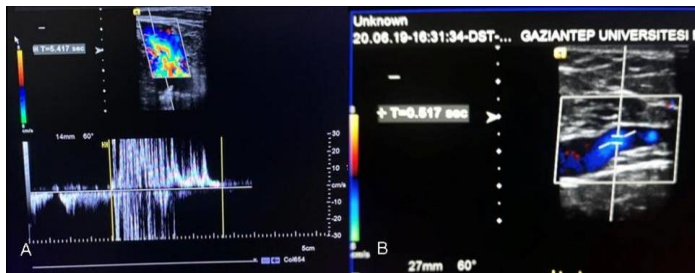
Preoperative and postoperative ultrasonographic examination of reflux at the SFJ level; A: Preoperative reflux; B: Postoperative reduced reflux
